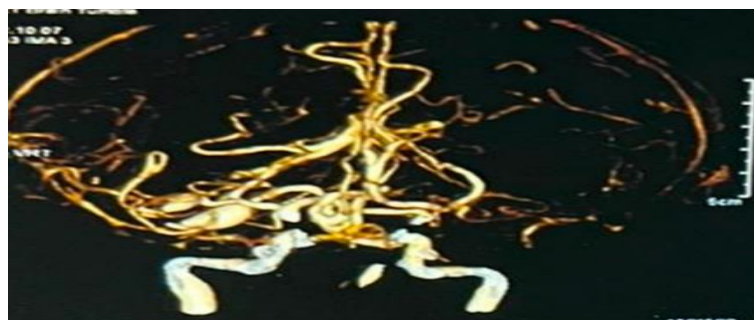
CTA of the patient showing occlusion from left MCA M1 segment (green circle) and aneurysms on right PCA and MCA (red circle)
